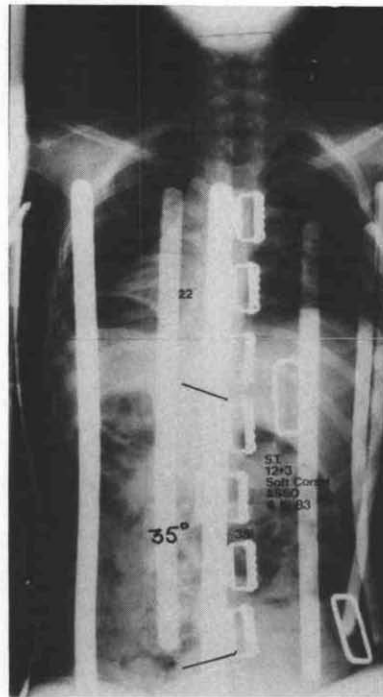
Spine x-ray of S.T. sitting in the support system we provided. The scoliosis is reduced to 35° and the lateral pelvic tilt to 14°.
